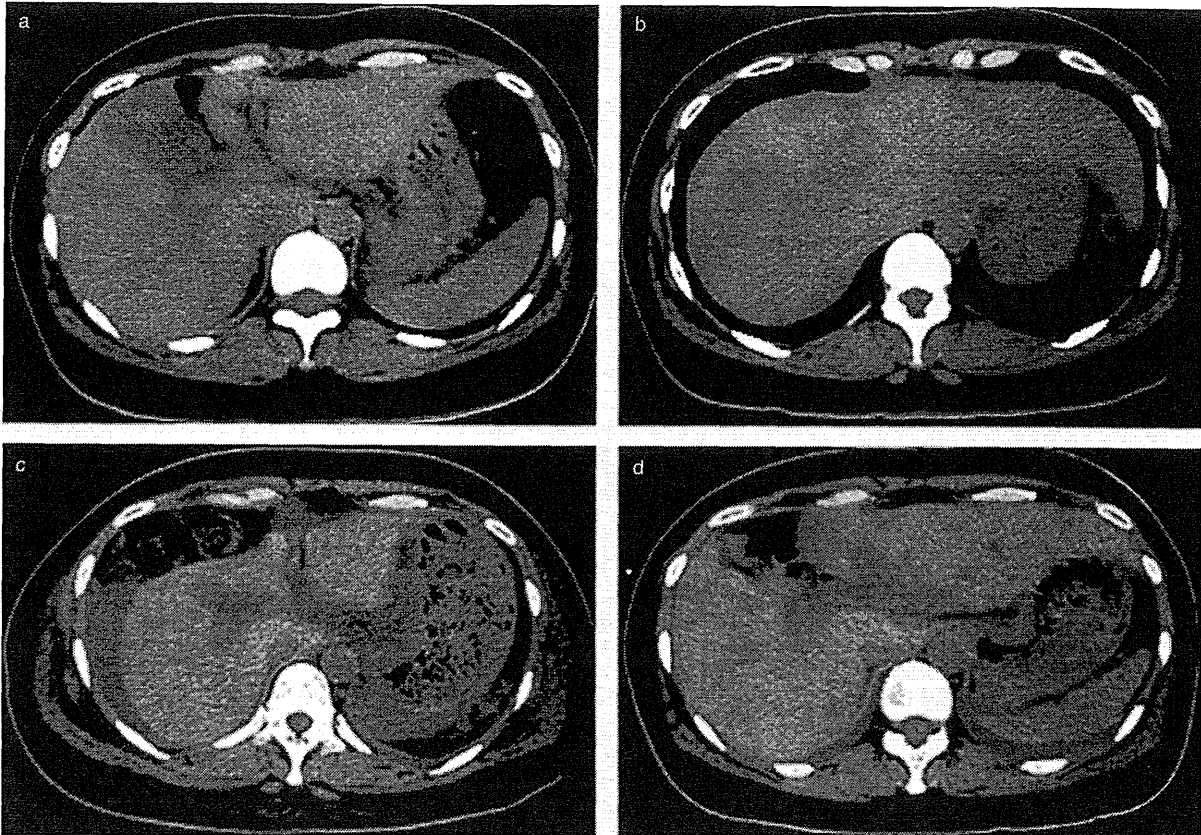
Computed tomography (CT) findings of a 49-year-old female patient with autoimmune fulminant hepatitis. Corticosteroid was administered and her liver function tests improved gradually. (a,b) CT scan showed heterogeneous hypoattenuating areas at admission. (c) One week after the administration of corticosteroid, her liver function tests improved gradually in response to the therapy. Nevertheless, liver atrophy of the right lobe progressed. (d) An enlargement of hyperattenuating areas and a decrease in hypoattenuating areas were found 2 weeks after.
